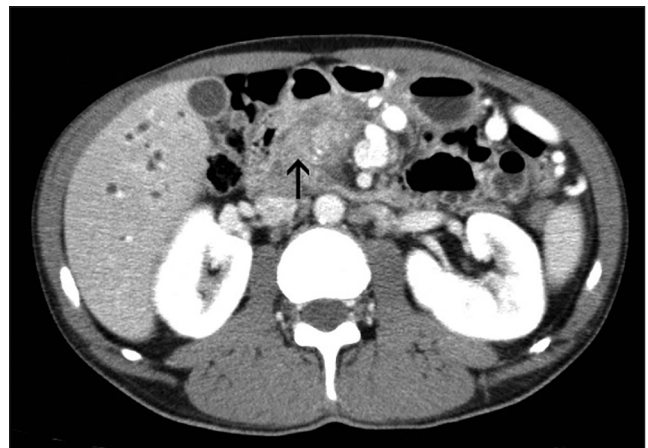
Axial contrast-enhanced CT image showing a hypodense lesion (arrow) in the pancreatic head with biliary tree dilatation
